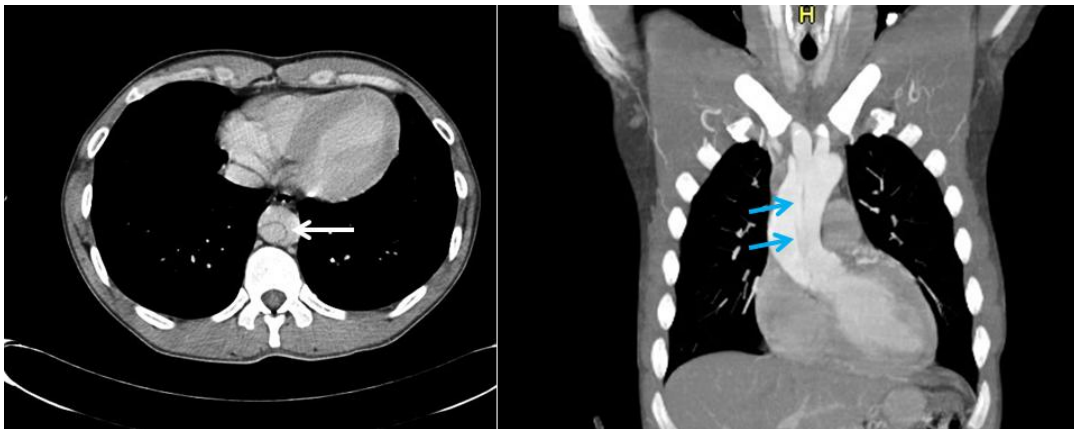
Type A Stanford dissecting aneurysm of aorta. Note the double lumen in the axial image of angiographic CT (white arrow; left part of the image) and the double contrasting in the sagittal reconstruction view (blue arrows; right part of the image)
